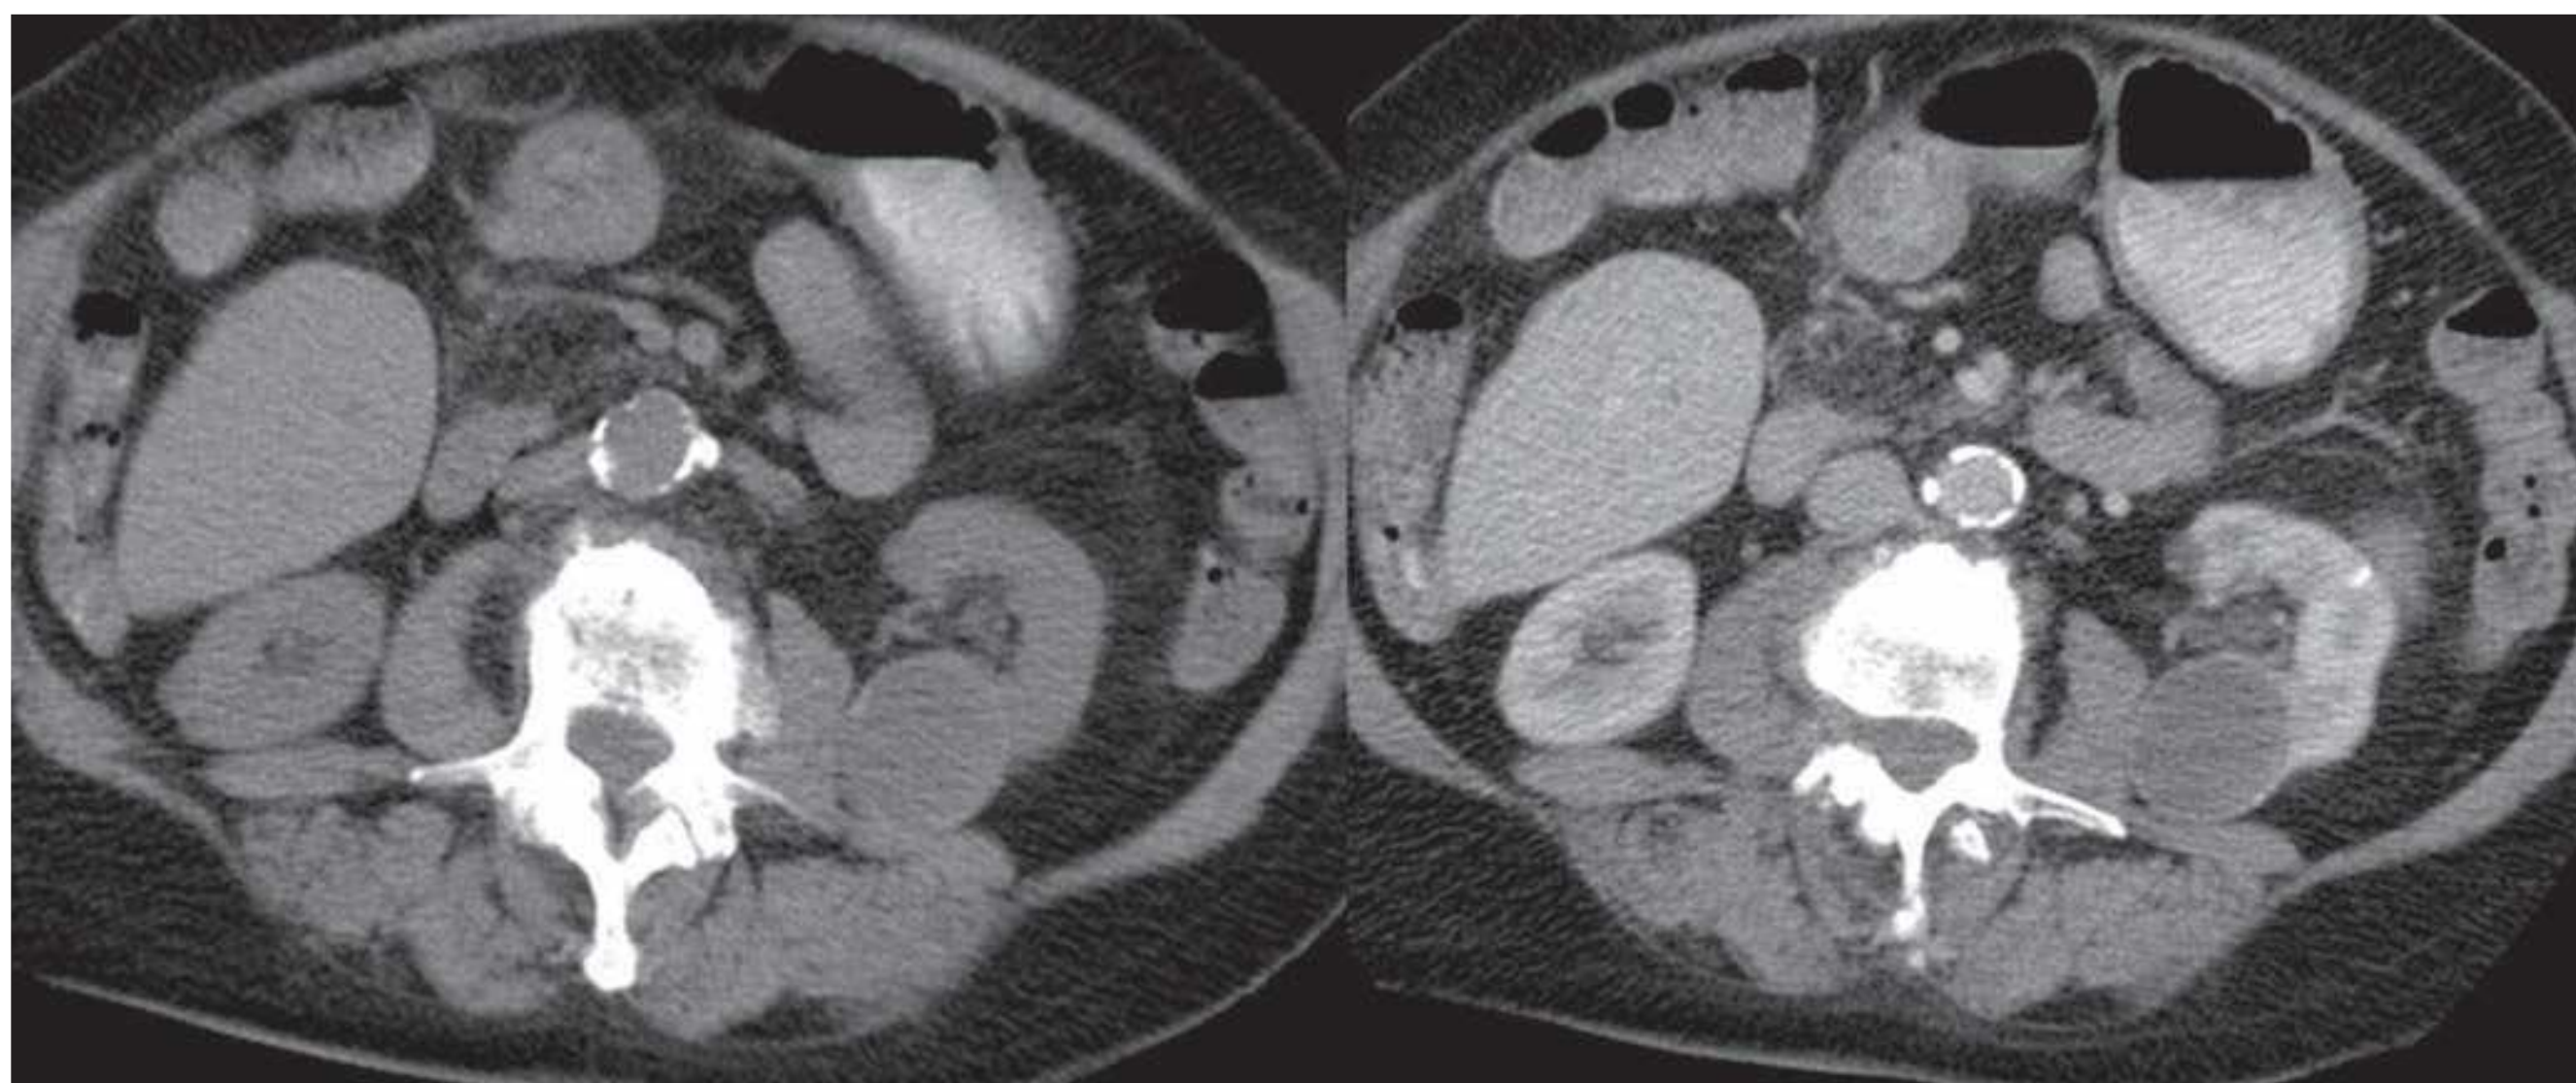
Bosniak class II cyst in the left kidney with slightly higher attenuation contents and subtle peripheral hyperdense rim on the pre-contrast CT but no contrast enhancement on the post-contrast CT.
